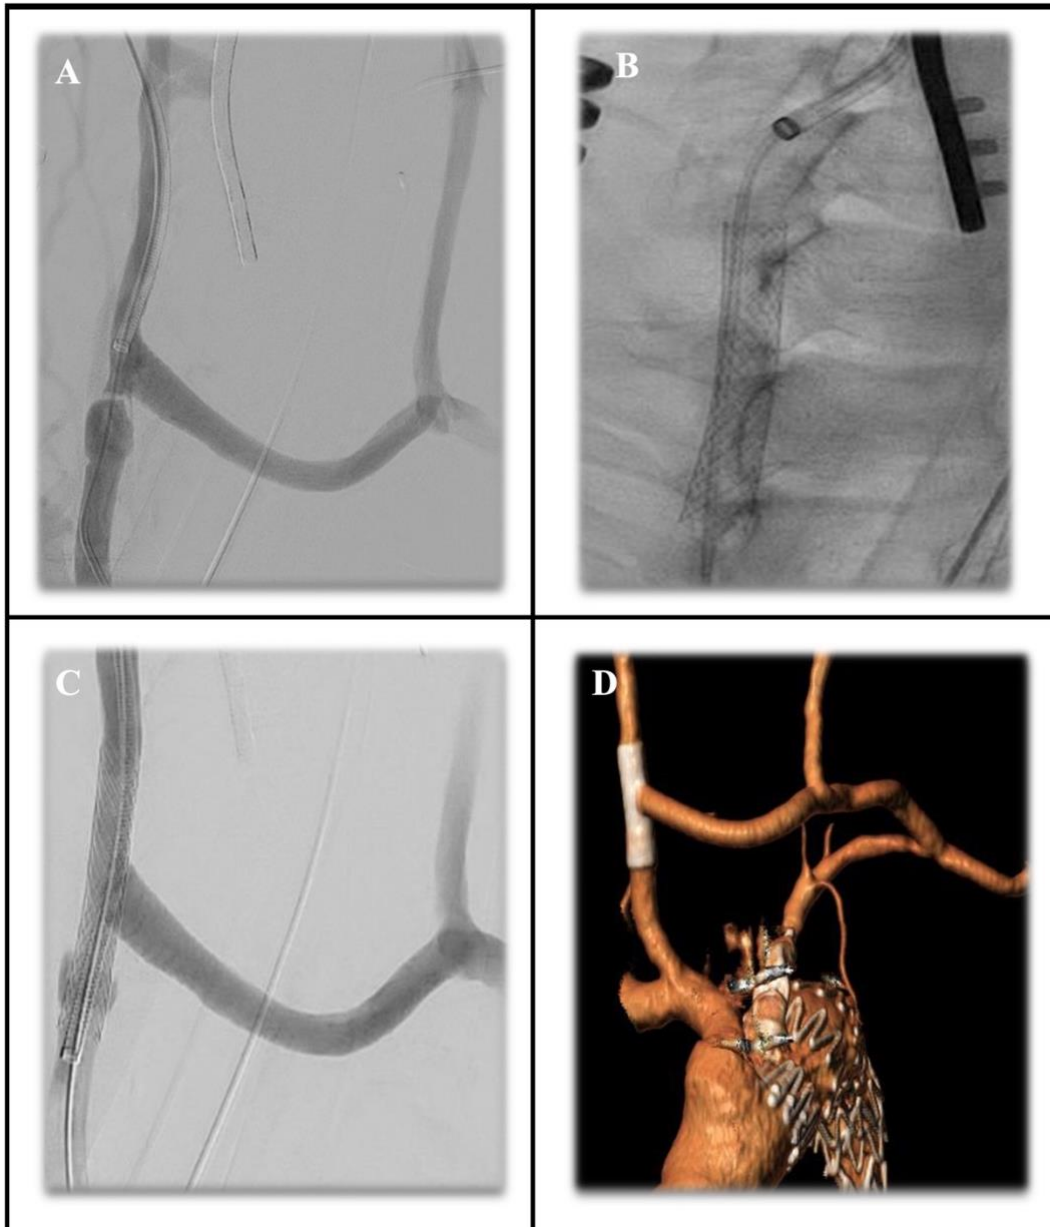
Patient with early supra-aortic-vessel debranching complication: A) dissection at the level of the proximal anastomosis on the right common carotid artery over a carotid-carotid-subclavian bypass; B) placement of Wallstent 9x40mm; C) Control angiography and D) Post-operative computed tomography angiography showing patency of the bypass e complete resolution of the symptomatic dissection.
